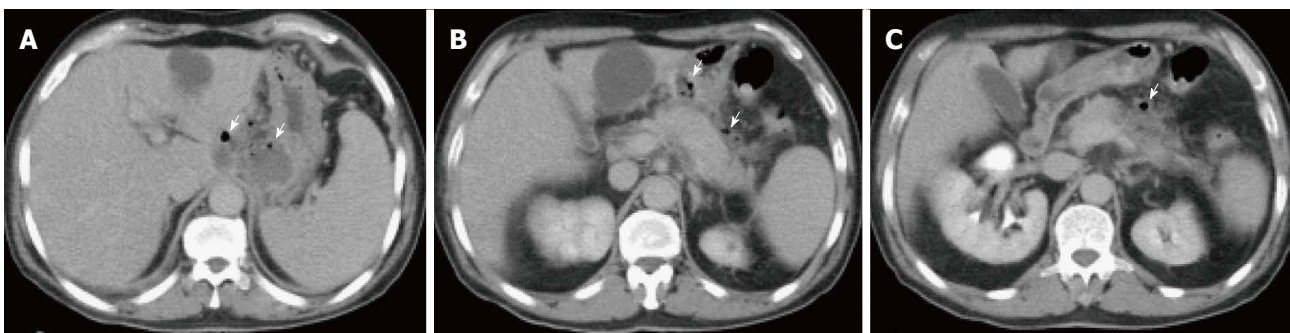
Infected peripancreatic fluid in a patient with acute pancreatitis. A-C: Axial CT scan during the portal venous phase. There are a few gas bubbles seen within a small peripancreatic fluid (arrows, A-C). In the absence of any intervention in keeping with infected peripancreatic fluid.
